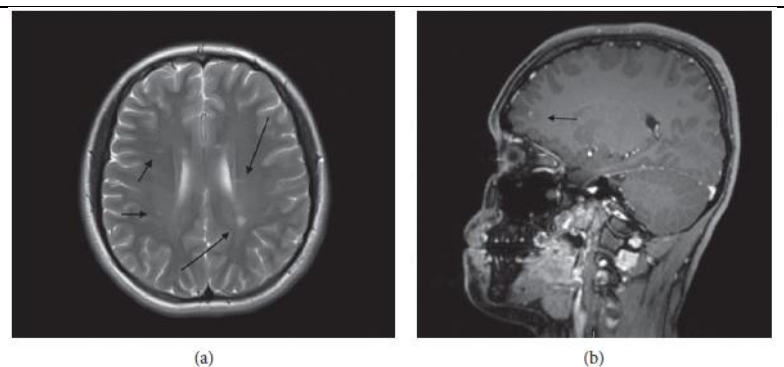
(a) there are multiple periventricular, subcortical, and juxtacortical white matter foci of T2 and FLAIR hypersignal in both cerebral hemispheres, brain stem, bilateral middle cerebellar peduncles, corpus callosum, and left anterior thalamus. (b) *ere is focal enhancement noted in the left peritrigonal white matter lesion.
